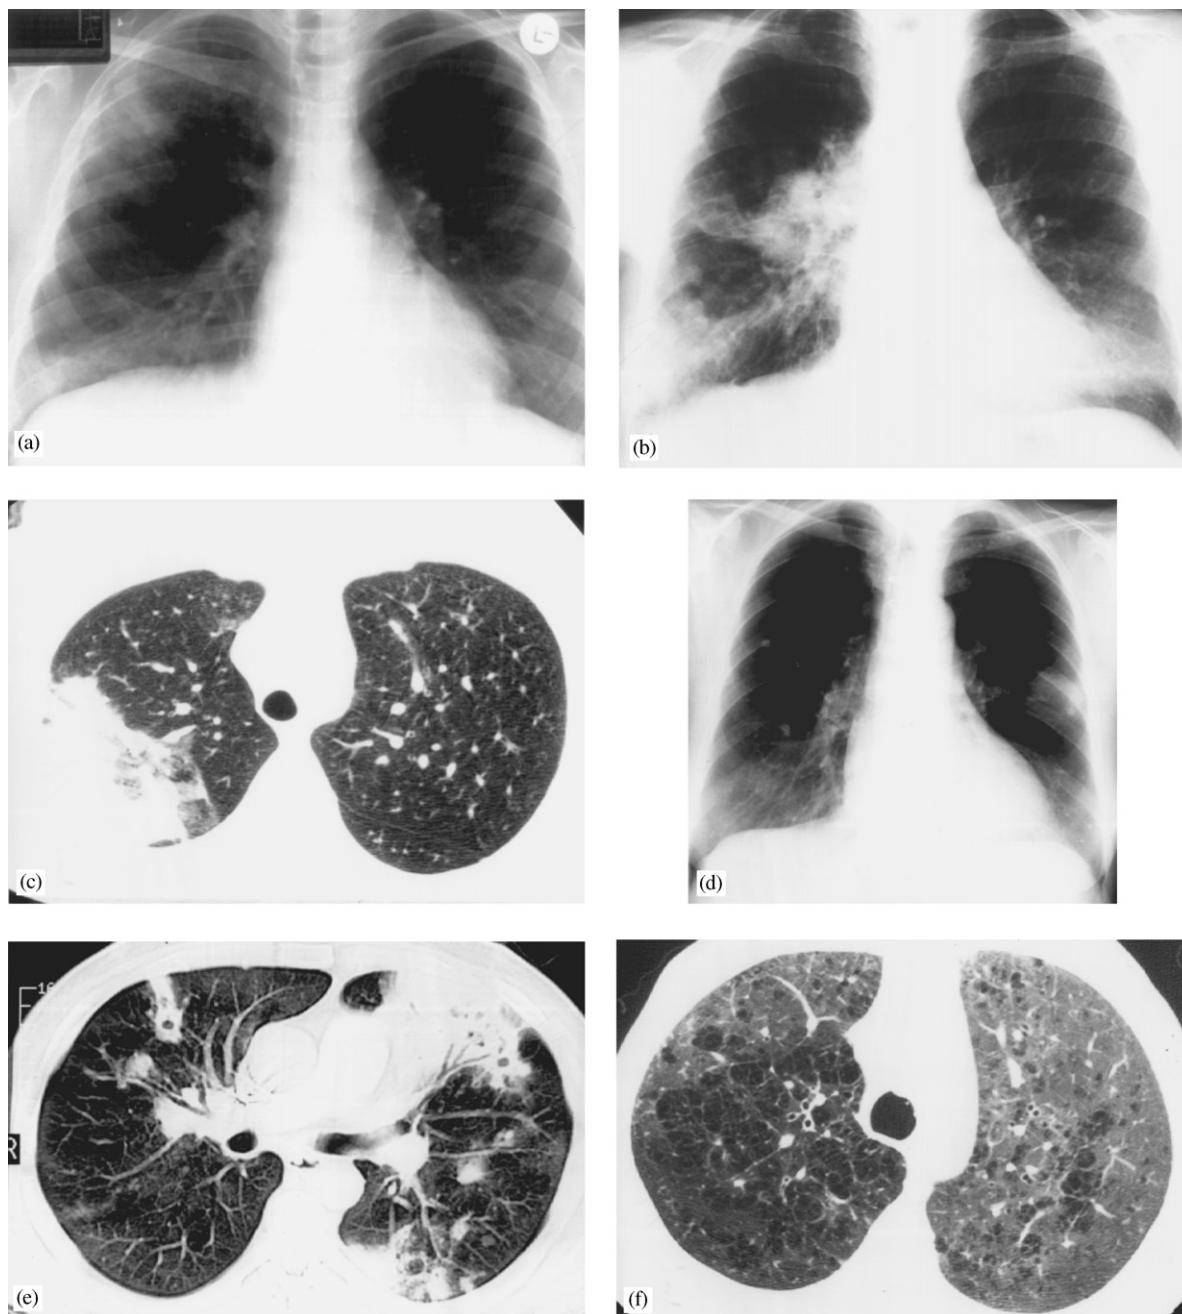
The diverse radiological manifestations of pulmonary nocardiosis. (a) Chest radiograph: non-segmental air-space consolidation right upper and lower lung zones. (b) Chest radiograph: mass-like consolidation at the right hilum, with multiple nodules and non-segmental consolidation in the right lower lung zone. (c) CT chest: consolidation abutting the pleura. (d) Chest radiograph: SPN; the background of multiple calcified nodules was due to unrelated healed granulomatous disease. (e) CT chest: multiple cavitating pulmonary nodules with consolidation (case 26). (f) CT chest: ground-glass opacity (case 23) is an unusual manifestation of nocardiosis. The abnormalities resolved with anti-*Nocardia* treatment. Background centri-lobular emphysematous change was also noted.
